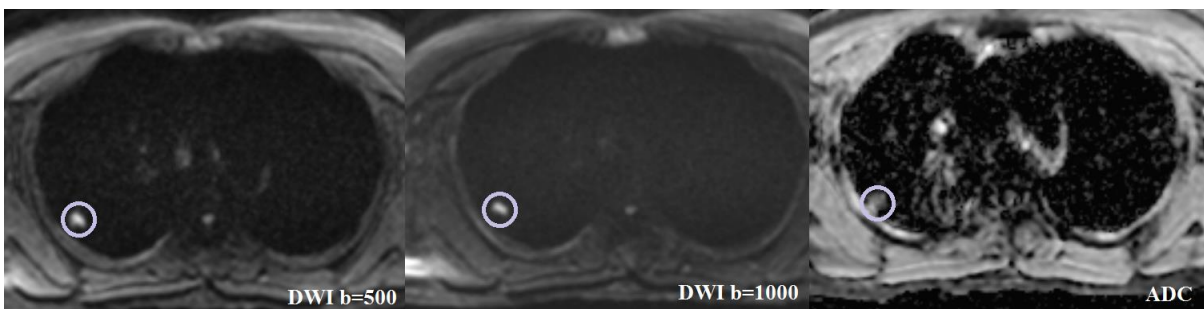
Diffusion weighted images showing diffusion restriction (hyperintense on DWI with corresponding dark areas on ADC).The values obtained from ROI placed within the solid area shows the following values.
